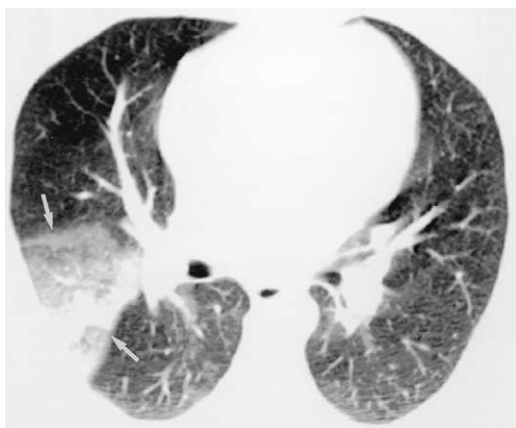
Multidetector spiral CT image shows a wedge-shaped pulmonary opacity abutting the pleural surface in the posterior segment of the right upper lung lobe (arrows). Occlusive thrombus was present in the posterior segmental artery to the right upper lobe.
